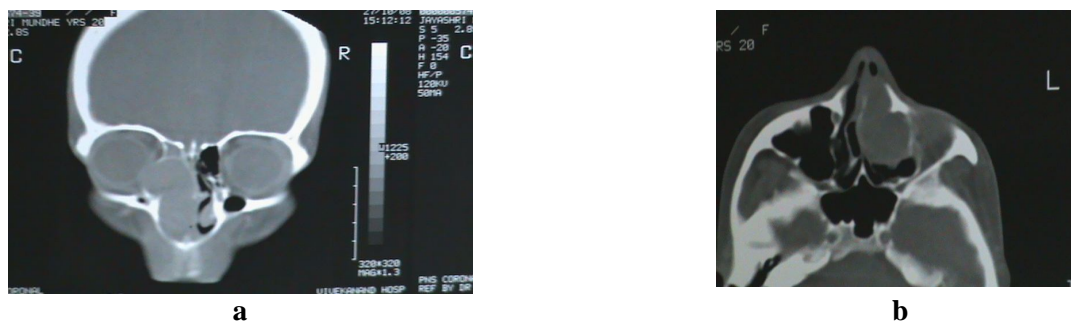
(CT Scan showing mass arising from the lateral wall of left nostril extending into the orbit through lamina papercia)
